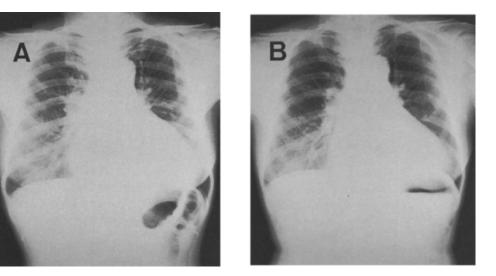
Chest x-ray films obtained before 21 days operation (A) and after 7 days operation (B) showing cardiac enlargement and slightly pulmonary congestions (A) and slight improvement of cardiomegaly (B).
